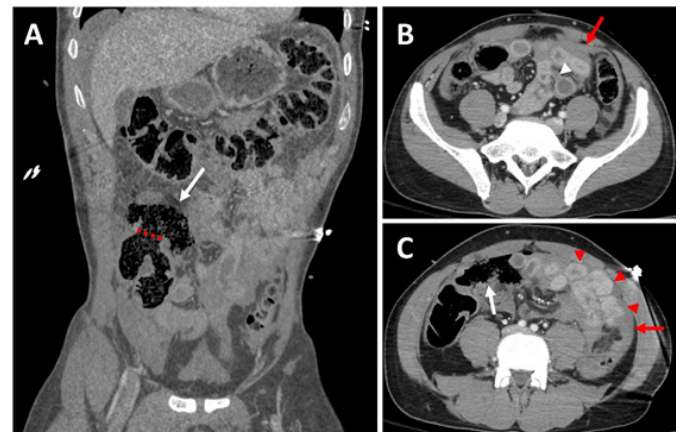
Intestinal and mesenteric injury after blunt abdominal trauma. (A) Contrast-enhanced abdominopelvic CT, coronal section showing a loss of continuity of the wall of the cecum (dotted line) with the outflow of intraluminal material into the peritoneal cavity (white arrow). (B and C) Same patient, axial sections show a solution of continuity of the wall of a loop of ileum (white arrowhead) and abundant haemoperitoneum (red arrow). Diffuse thickening of the small bowel loops (red arrowhead) secondary to the mesenteric vascular lesion is also visualized.
